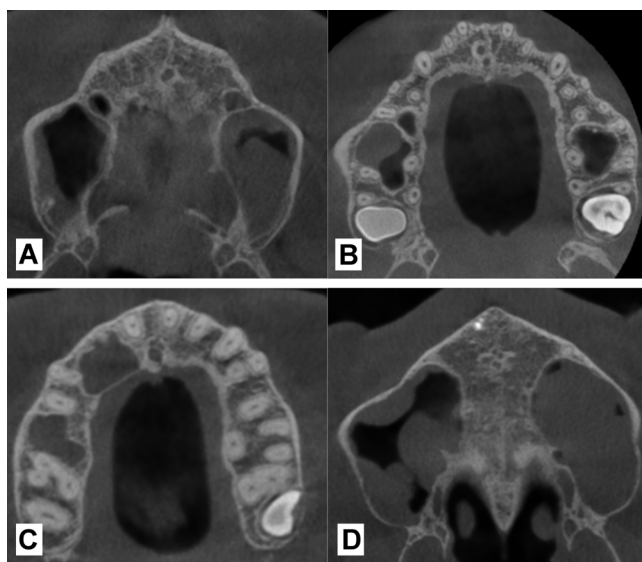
CBCT images of Stenson's foramina in the axial plane
